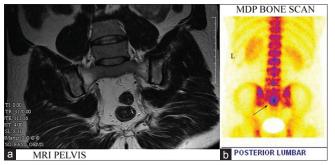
(a and b) Lumbo-sacral contrast enhanced magnetic resonance imaging and Tarlov cyst methylene diphosphanate bone scan images showed a cystic lesion in right neural foramen lesion at S2 level, 25 mm × 15 mm × 25 mm in size with hot spot in bone scan, whose intensity was the same as cerebrospinal fluid. Similar lesions were also noted in S1, right T3-T4, right T7-T8 and left T6-T7 neural foramina but with no hot spots in methylene diphosphanate bone scan
